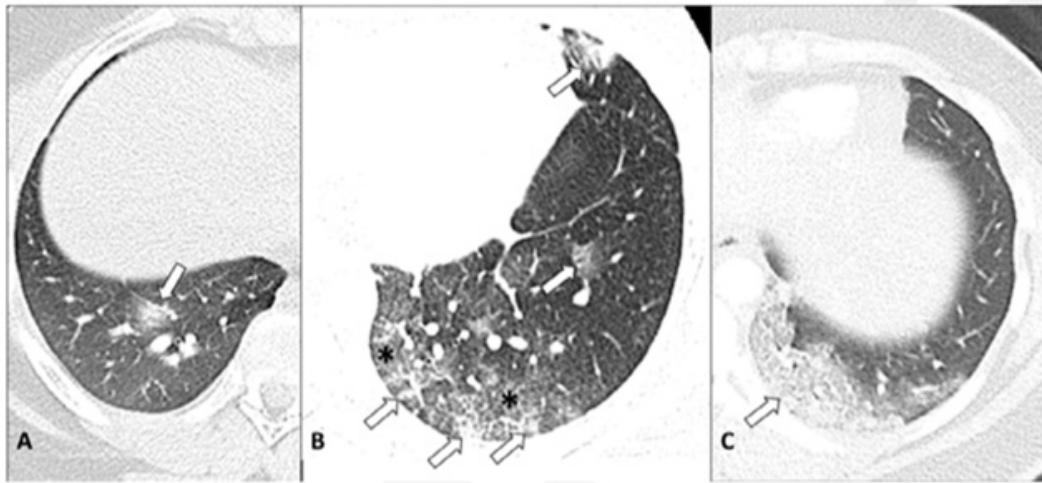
Computed tomography images in 3 different patients in 3 different stages of COVID-19 pneumonia (early, progressive, and advanced). (A) Findings of early phase COVID-19 pneumonia in a 14-year-old girl with Hodgkin lymphoma diagnosed with PCR (+). The patient presented with fever and cough. In the axial section, GGO (arrow) and ill-defined central consolidation are compatible with the “halo” sign. (B) In the progressive phase, a 15-year-old PCR (+) girl has a travel history to Europe. She presented with an increasing cough and shortness of breath. In the axial section, there are GGOs (arrow) and central consolidation areas. Among these areas, GGO (asterisks) started to fill the lung parenchyma. (C) A 16-year-old PCR (+) girl was brought with severe shortness of breath. In the axial section there are areas of confluent consolidation in the lower left posterior lobe (arrow). Findings are consistent with advanced stage COVID-19 pneumonia.
